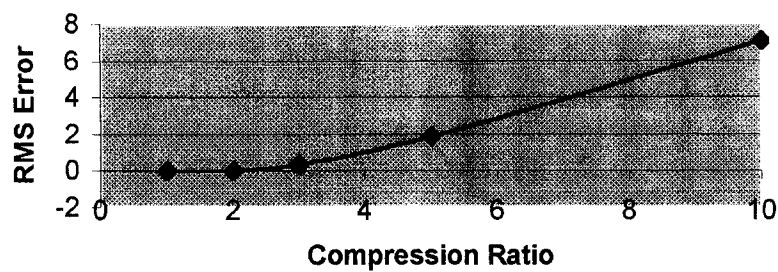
A graph of the root mean square compression error for a typical abdominal CT image as a function of compression ratio. Experimental tests show that at ratios of 2.5 and below, the compression is lossless (RMS Error = 0).
